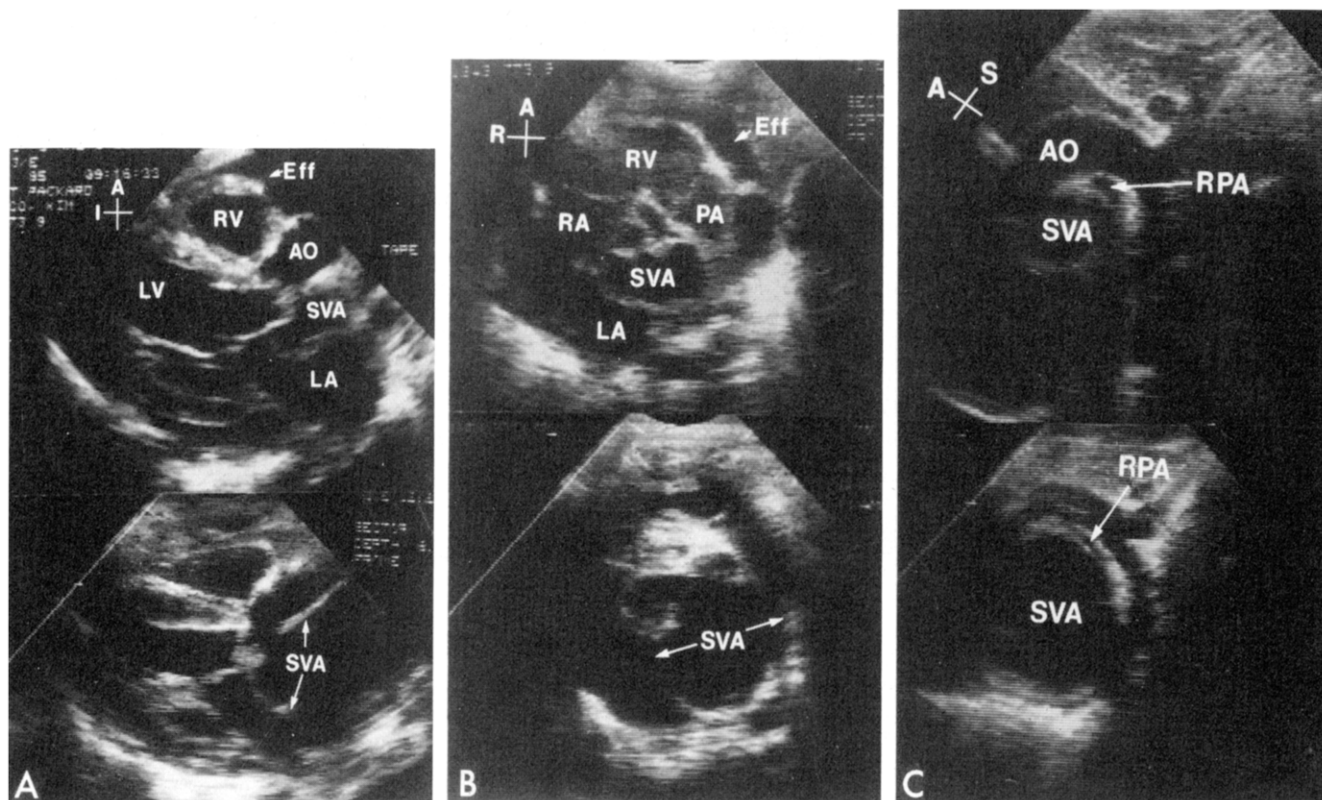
Serial two-dimensional echocardiograms. Parasternal long-axis views. A: Top, First hospital day. The dilation in the posterior portion of the ascending aorta (AO) is a sinus of Valsalva (SVA) aneurysm. There is a moderate-sized pericardial effusion (Eff), and the aortic valve leaflets are thickened. Bottom, 11th hospital day. The sinus of Valsalva aneurysm (SVA) has enlarged considerably. The aortic valve leaflets are prolapsing into the left ventricle (LV). B: Parasternal short-axis views. Top, First hospital day. The posterior and leftward dilation in the ascending aorta is a sinus of Valsalva (SVA) aneurysm. A moderate-sized pericardial effusion (Eff) is present. The aortic valve is bicuspid. Bottom, 18th hospital day. The sinus of Valsalva aneurysm has enlarged considerably and is impinging on the right pulmonary artery. C: Suprasternal long-axis views. Top, First hospital day. The sinus of Valsalva (SVA) aneurysm is seen bulging from the ascending aorta (AO) in a posterior and superior direction. There is some encroachment on the right pulmonary artery (RPA). Bottom, 18th hospital day. The right pulmonary artery (RPA) is markedly narrowed by the expanding sinus of Valsalva aneurysm. There is now encroachment on the descending aorta as well. A = anterior; I = inferior; LA = left atrium; P = posterior; PA = main pulmonary artery, R = right, RA = right atrium, RV = right ventricle; S = superior.
